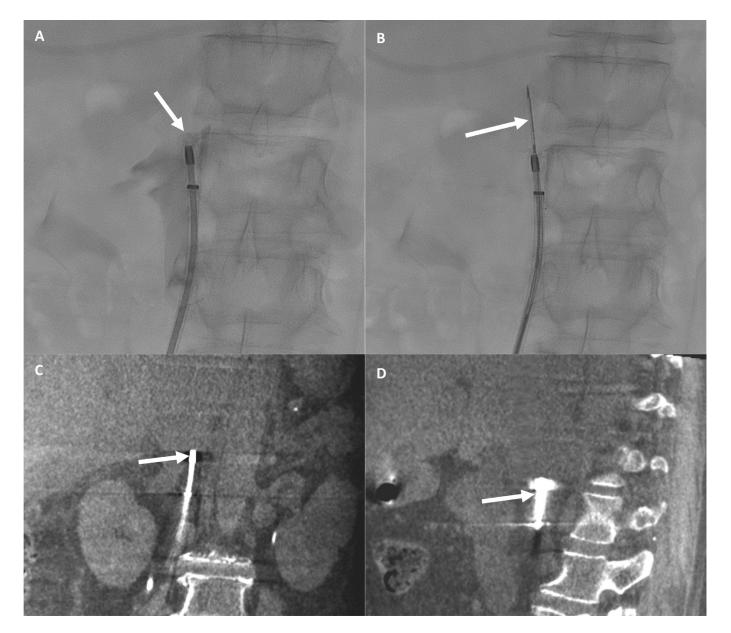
Transvenous biopsy; Case #1. (A) Position of the biopsy cannula inferior to the mass, with venogram showing the filling defect due to the mass (arrow). (B) Biopsy needle (arrow) deployed into the mass. (C) Intraprocedural coronal cone-beam CT confirming position of the biopsy cannula inferior to the mass (arrow) prior to needle deployment. (D) Intraprocedural sagittal cone-beam CT confirming position of the biopsy cannula inferior to the mass (arrow) prior to needle deployment.
